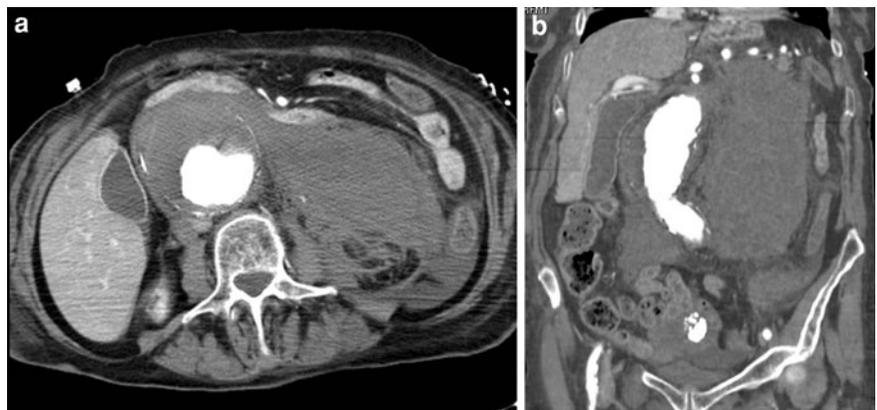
Abdominal aortic aneurysm. Axial CT scan (a) and multiplanar coronal reconstruction (b) show the rupture of an abdominal aortic aneurysm, with a large hemoretroperitoneum
